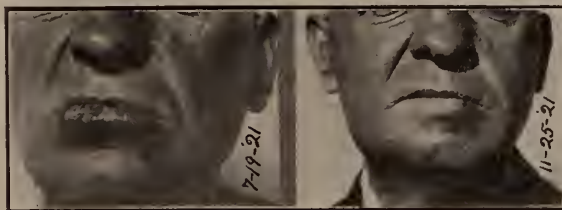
7/19/21. Epithelioma of the lip. Duration four months. (b) 11/25/21. Complete disappearance under radium applications internally and externally, with deep Roentgentherapy applied in the submental and submaxillary region. Still well.
